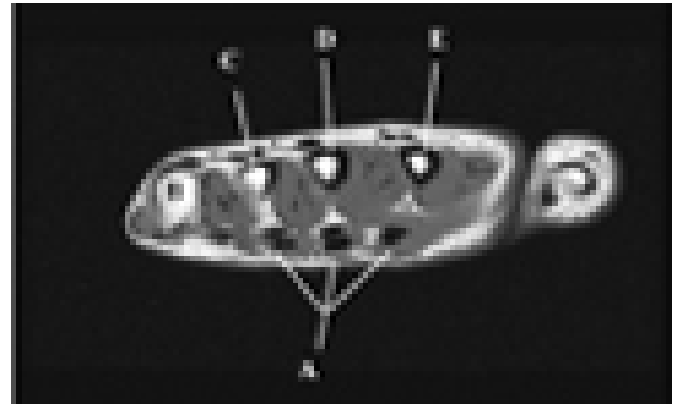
T1-weighted axial through hand at mid metacarpals. A-flexor digitorum tendons, B-head of 5th metacarpal, C-4th metacarpal, D-3rd metacarpal, E-2nd metacarpal
